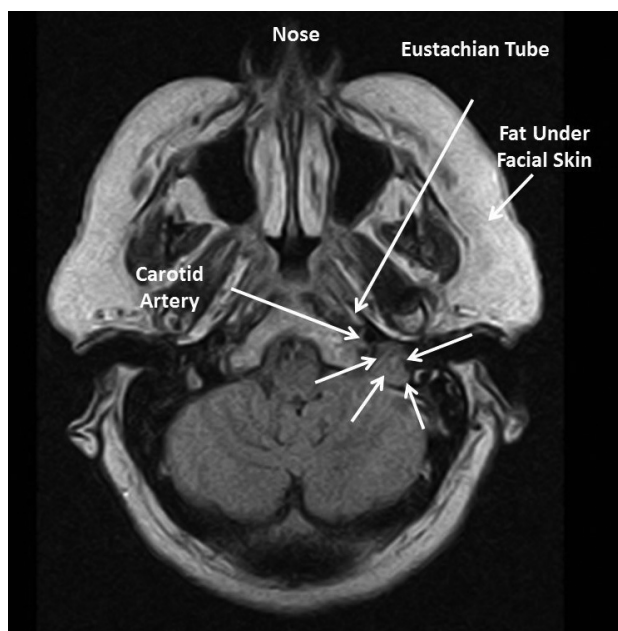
Non-contrast axial FLAIR MRI of the temporal bone did not reveal a mass in the temporal bone.
